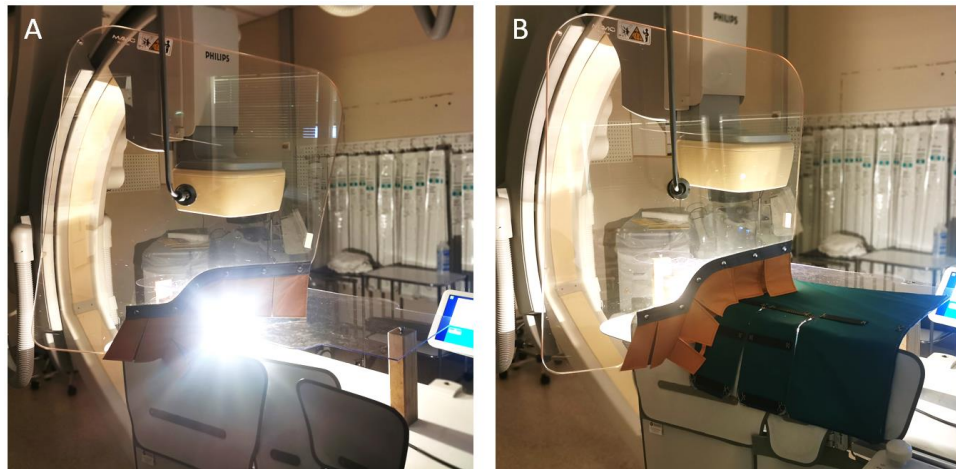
Mode of action of an X-ray blanket positioned above the patient. In panel A, photons exit the patient between shielding devices and reach the operator. In panel B the X-ray blanket covers the unshielded area between the ceiling- and table-mounted shield thus enhancing operator protection.
